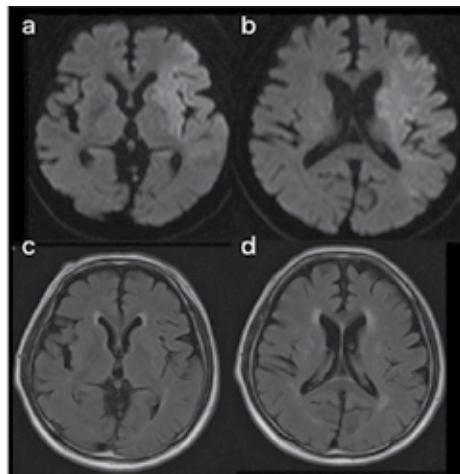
Diffusion-weighted MR image (a, b) and FLAIR image (c, d) on admission. Acute ischemia was noted in the left middle cerebral artery on diffusion-weighted MR image (a, b); however, no lesions were detected on FLAIR image (c, d), suggesting hyperacute ischemia.
